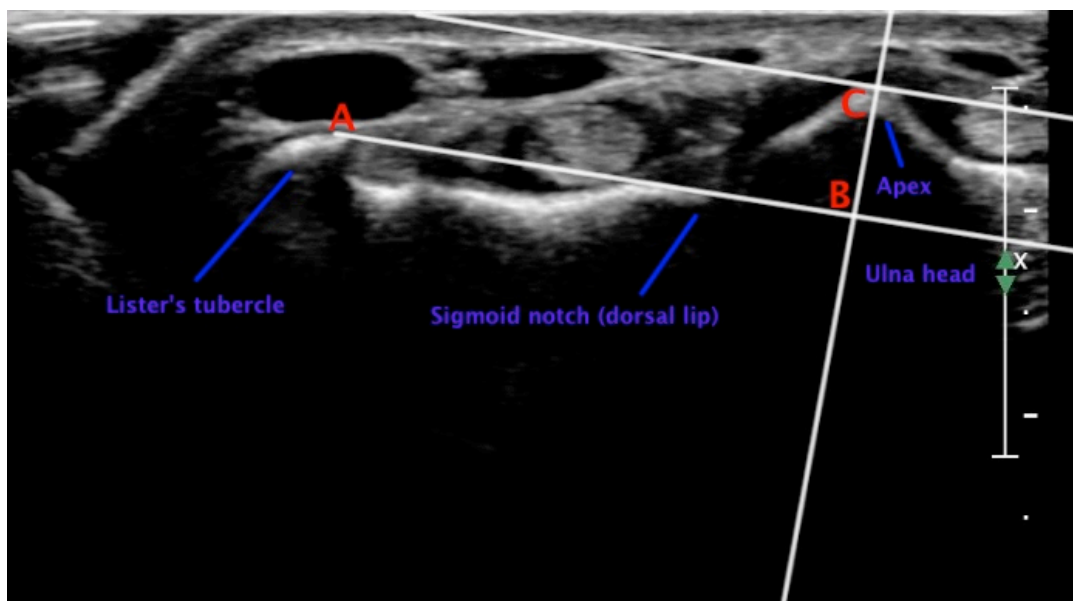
Analysis of ultrasound image: Lines drawn relative to established bony landmarks indicating DRUJ displacement modified from the RASR method explained by Henmi et al, (2007). Translation was measured in mm between points of B and C. Ratio values to assess validity consistent with the RASR method used distance in mm of BC/AB
